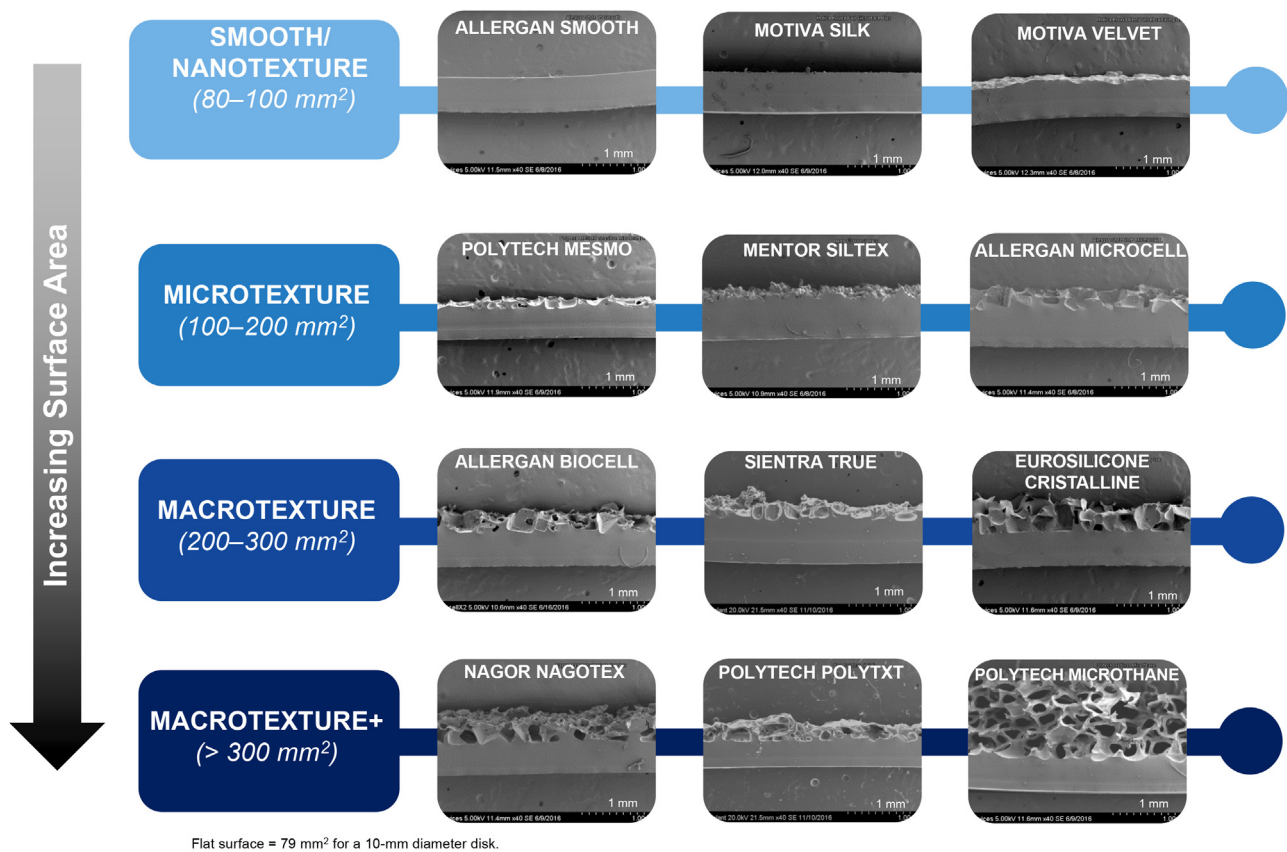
Classification of implant textures based on texture surface area. SEM images of the cross section of each implant texture are organized into categories according to the magnitude of the texture surface area measured from the anterior of the shell by X-ray computed tomography.
